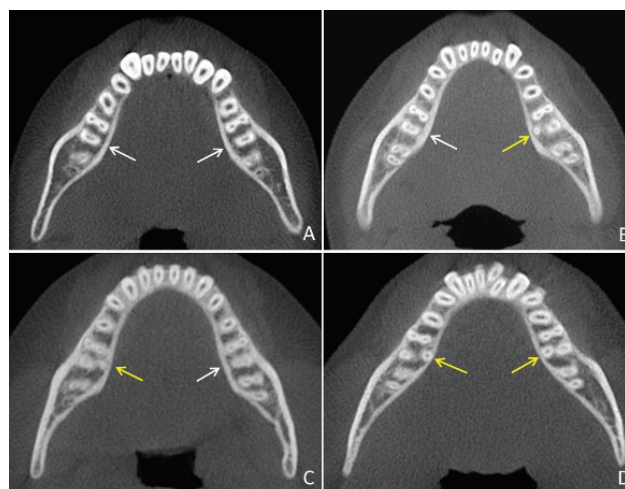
Axial CBCT images. (A) No RE, (B) unilateral RE on the left side, and (C) unilateral RE on the right side. (D) Bilateral RE (yellow arrows denote RE; white arrows denote no RE) RE: Radix entomolaris, CBCT: Cone beam computed tomography
